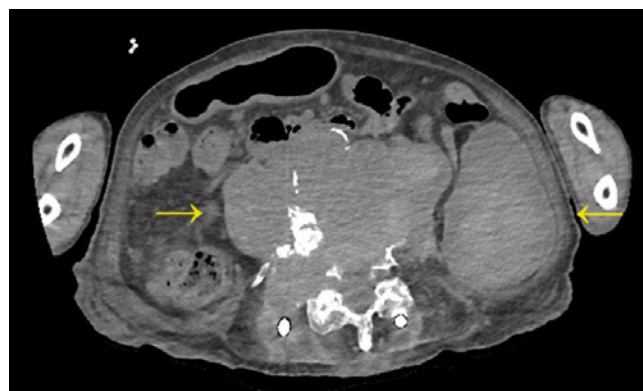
Sixty-one days after the injury, fifty days after the spinal surgery, simple CT, axial.
